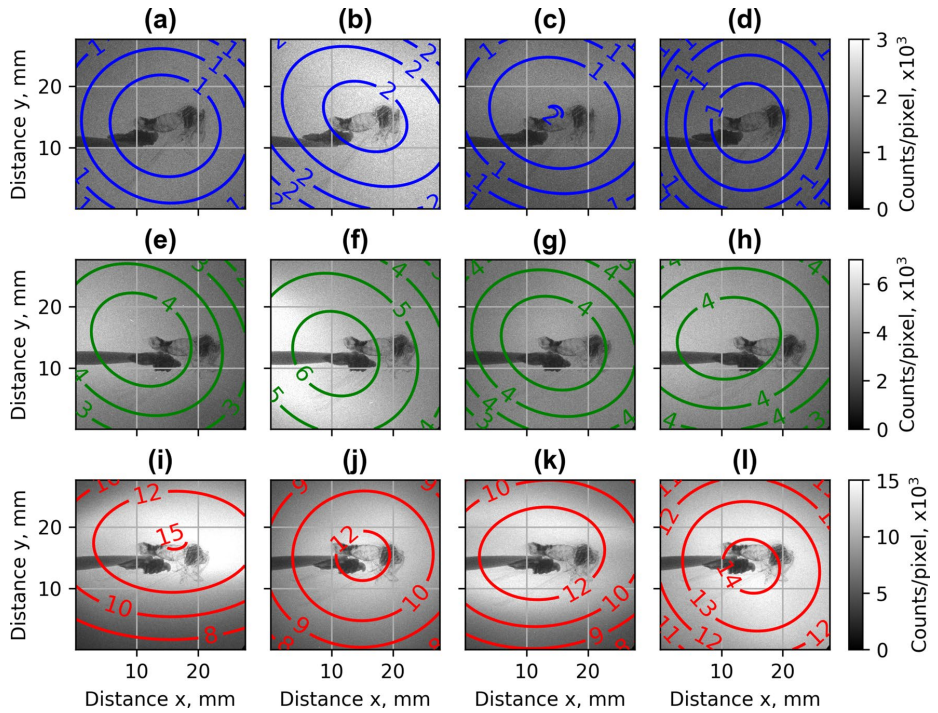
Examples of X-rays images, the colored ellipses represent regions with a number of counts per pixel higher than indicated (in thousands): single nozzle S1 (a–d), array Arr2 (e–h), and array Arr3 (i–l) at the distance of laser beam above the nozzle of 400 μm .
